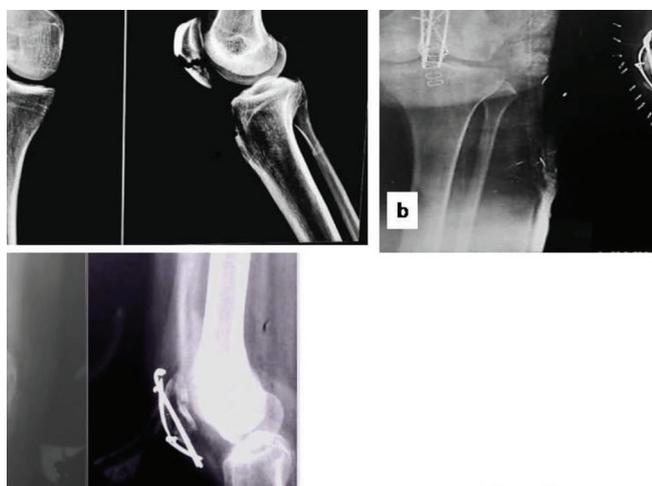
Comparison of pre-operative radiograph with post-op radiograph
